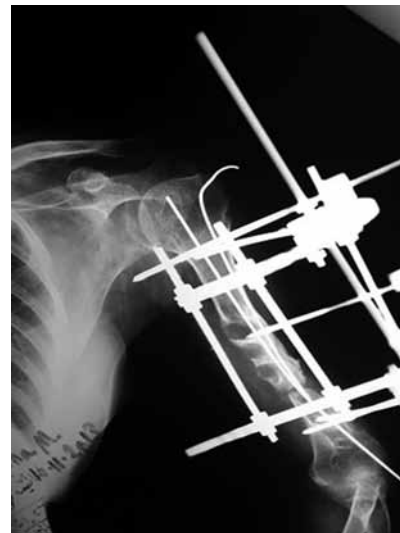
(c): Plain radiograph of left humerus of the same patient after removal of the failed implant & fixation by two intramedullary K-wires & Ilizarov frame
